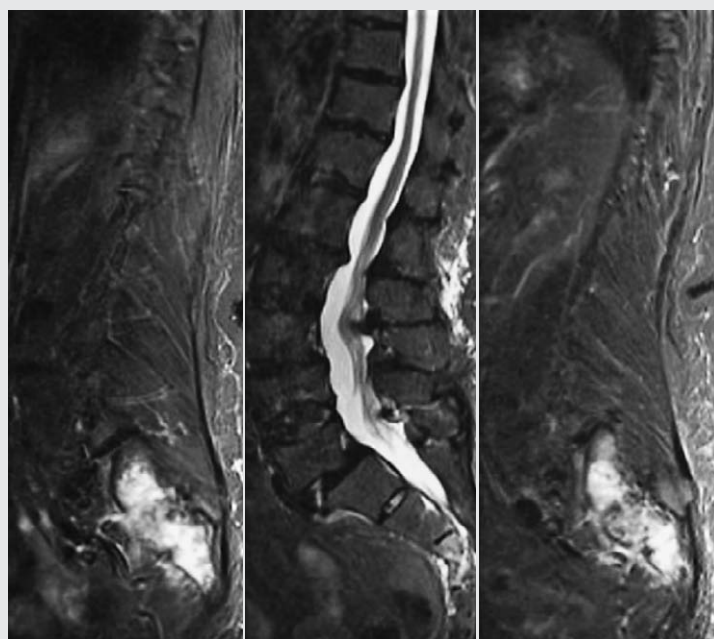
Pathologically increased signal of lateral masses of the sacrum shown on the MRI of the LS spine. Sagittal sections through the LS spine (STIR image) show a pathological increase in the signal of the lateral masses of the sacrum along with signs of discopathy and foraminal stenosis along the lumbar level of the spine.
